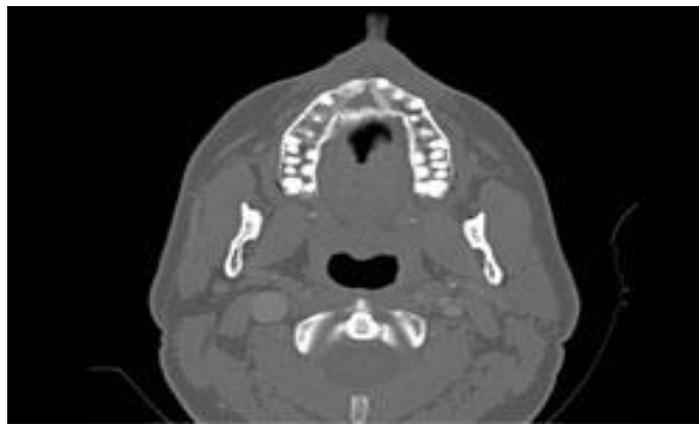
Contrast enhanced computed tomography scan revealed a mass confined to the soft palate
